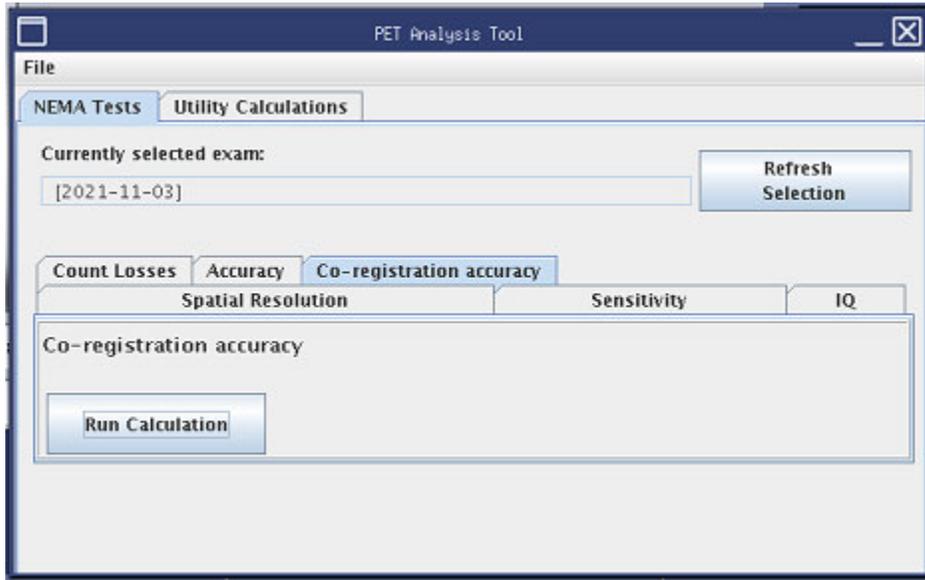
PET Analysis Tool - PET-CT co-registration tab selected
